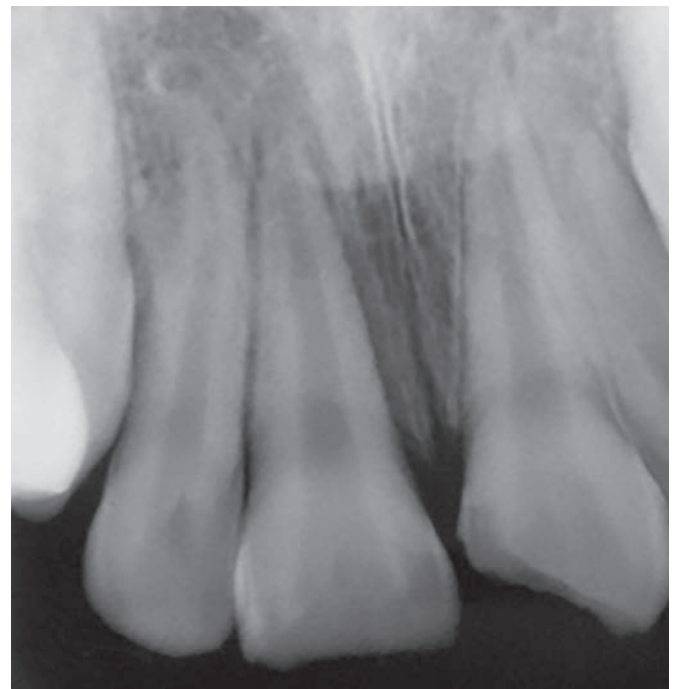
Initial periapical radiography.
